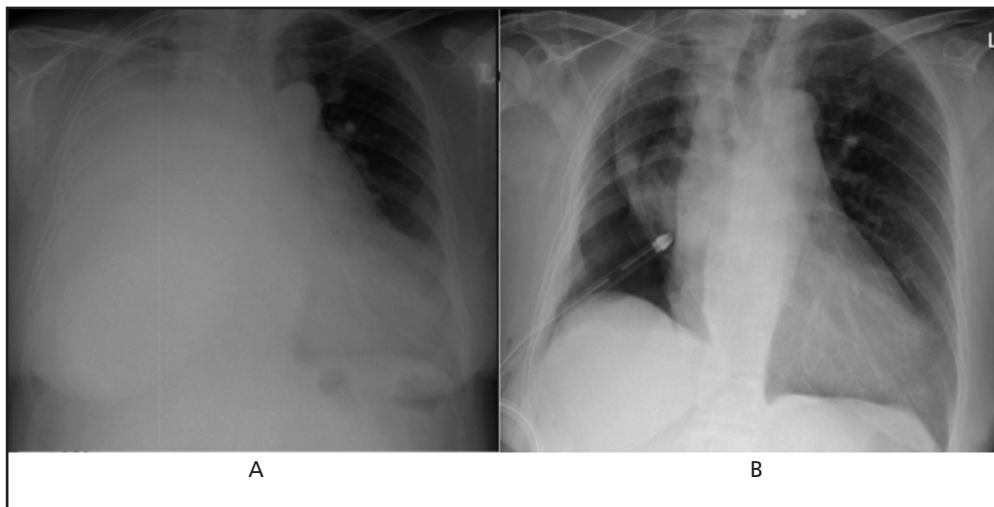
Chest radiograph (A) showed massive right-sided pleural effusion. Chest radiograph (B) post pleuroscopy and chest drain insertion showed non-expandable lung.
